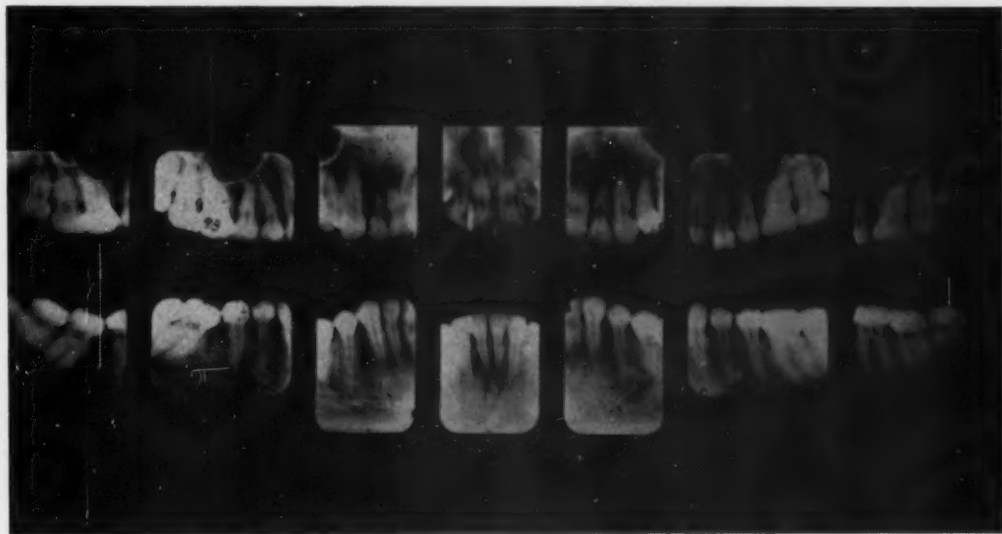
Patient H. B., aged 21 years. B.M.R., -14 (pituitary). Radiographic examination revealed resorbed roots and osteoporosis. There was a history of previous orthodontic treatment.
